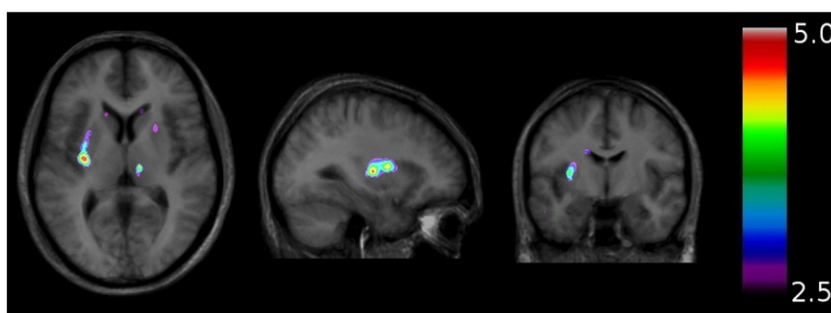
Increased [<sup>11</sup>C]raclopride BP (indicating decreased DA transmission) in the left dorsal putamen in the Reward versus Control conditions. The  $t$  statistic map was threshold to only show changes of  $t > 2.5$  (positive  $t$ -values reflect increased [<sup>11</sup>C]raclopride BP). In all images, the  $t$  statistic maps for BP change are overlaid on axial slices from an average MRI of the 10 subjects. Left and right on the images correspond to the real left and right sides.
